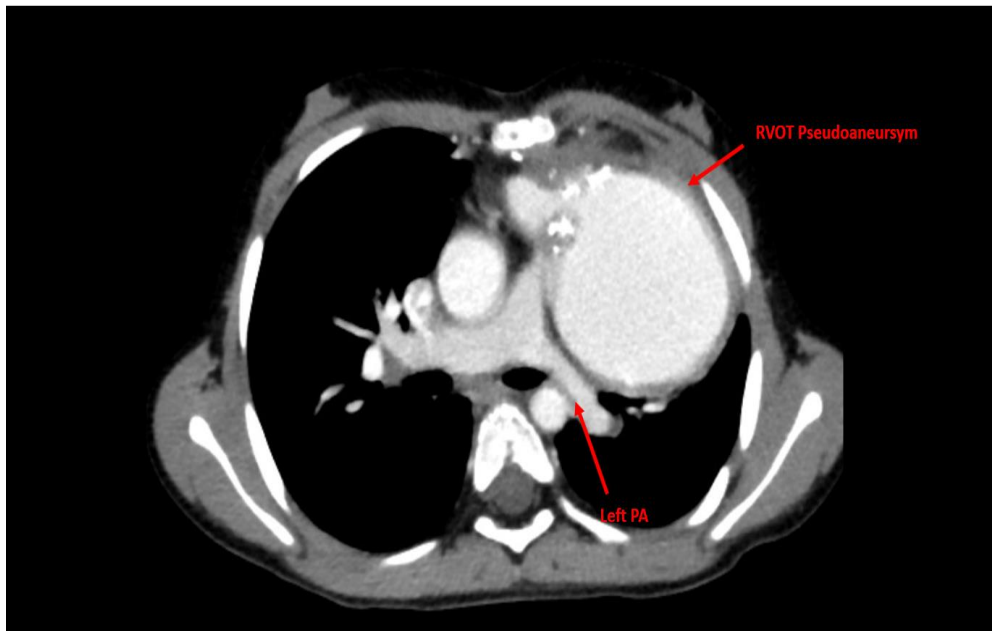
Thorax CT angiography image of RVOT pseudoaneurysm. RVOT: right ventricular outflow tract, PA: pulmonary artery.
